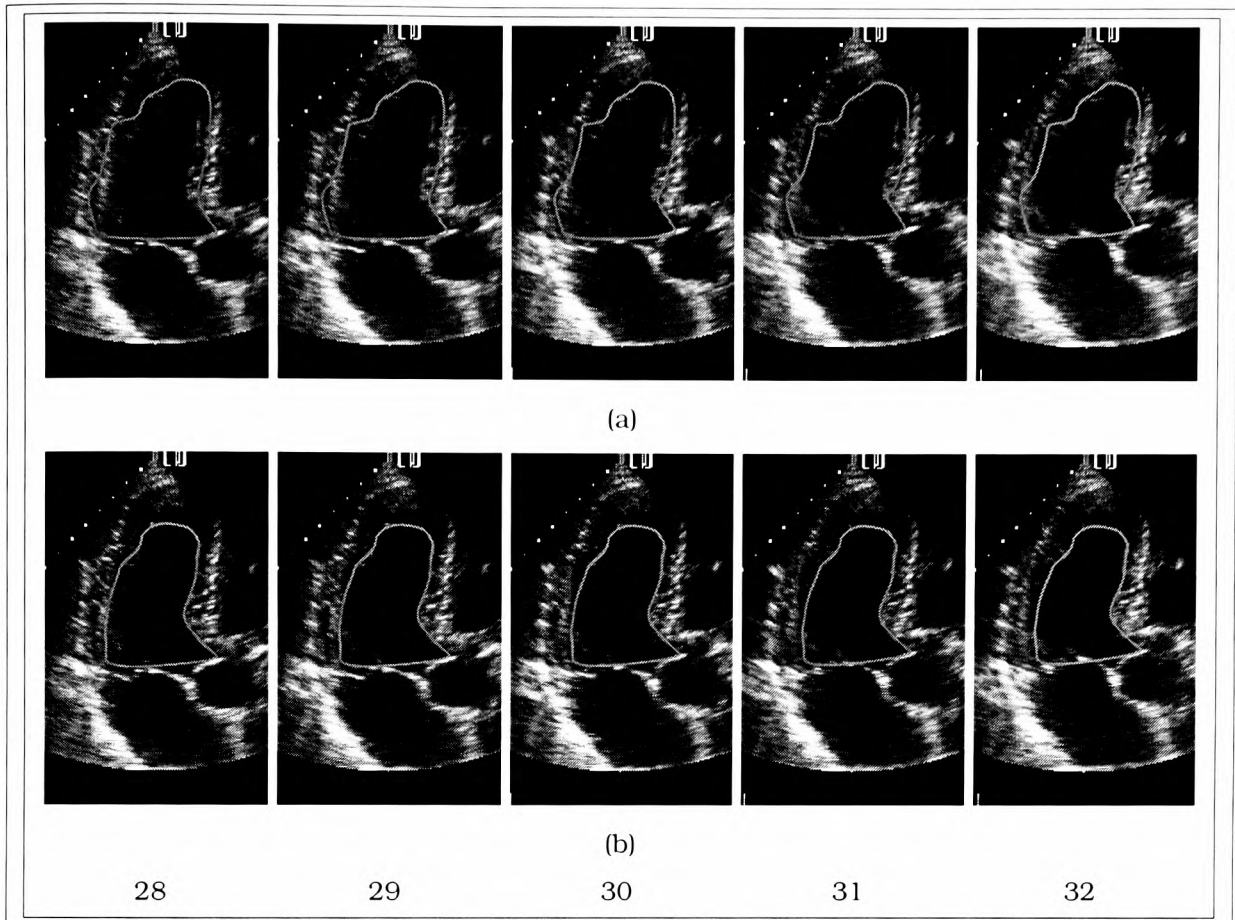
Clinical shape-spaces. An 8-dimensional clinical shape-space was created using the key-frames idea outlined in Section 4.3.1. The basis vectors were as follows; horizontal and vertical translation and 6 segmental scaling vectors. Tracking using this basis was visually compared to a PCA shape-space. Shown are 5 consecutive frames (28–32) during systole from an ultrasound sequence. (a) ‘Hand-made’ clinical shape-space. (b) PCA shape-space. The ‘hand-made’ clinical shape-space allows or too much deformation in the contour, and the tracker becomes unstable. In comparison, as expected, the PCA shape-space, being finely tuned to the object’s deformation, tracks well. The interpretational shape-space, described in Section 6.3, decomposes the tracking into clinically meaningful shape-space components.
